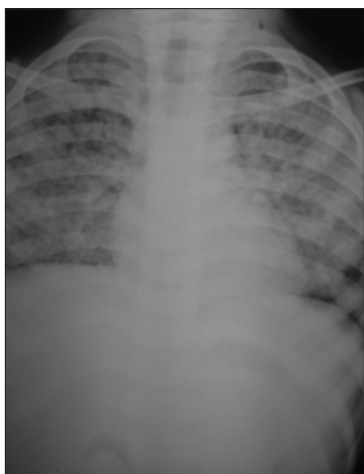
Miliary mottling on chest radiograph
